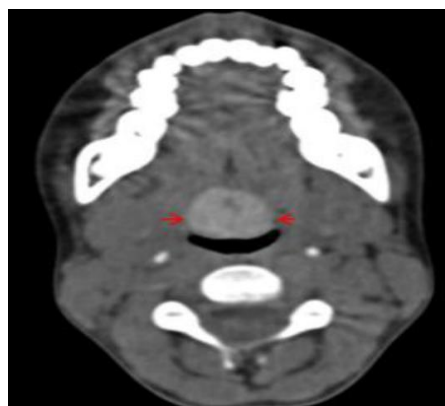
Shows Well-Defined Midline Base of the Tongue Mass showing High Density on Unenhanced CT Scan [Lingual Thyroid]
